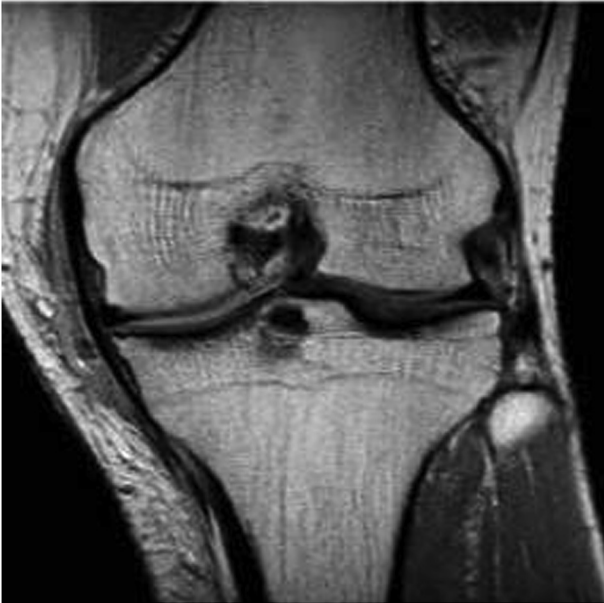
Coronal T1-weighted MRI of the case 1 obtained through mid-portion of the medial femoral condyle 12 months after medial MAT. We considered subluxation of more than 3 mm to indicate extrusion.¹⁴ Meniscal subluxation was defined as the distance from the tibial plateau to the outer edge of the meniscus. Secure integration of the allograft with the joint capsule and good positioning in relation to the tibiofemoral joint were evident. No frank extrusion of the allograft out of the tibiofemoral joint was evident.
